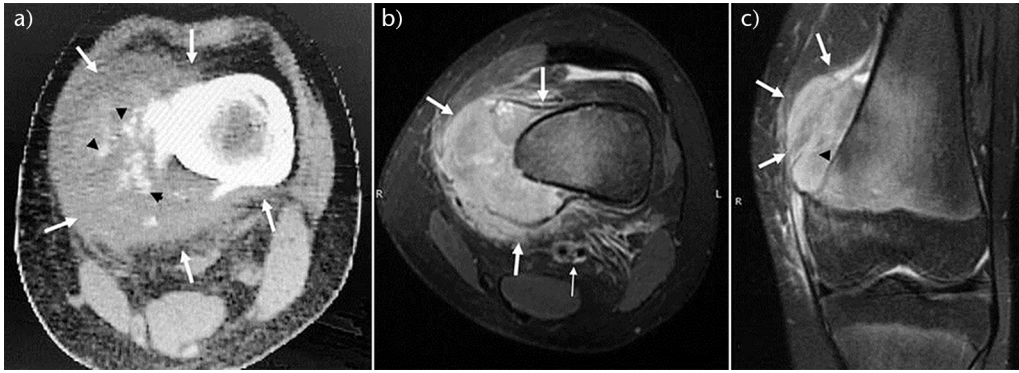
(A) A computerized tomography (CT) scan shows a cortical broad-based soft tissue mass (arrows) at the distal metaphysis of the left femur which surrounds about 50% of bone circumference. The tumour contains amorphous calcifications, and the adjacent cortex is thickened on this slice. (B, C) An axial (B) and a coronal (C) fat-suppressed T2w magnetic resonance (MR) image demonstrate the bulky tumour (arrows) originating at the medial site of the left femur. The tumour is moderately hyperintense and presents significant intramedullary extension (arrows). At the distal margin of the tumour on the coronal image the bone cortex looks thinned (C). The neurovascular bundle remains intact in B (thin arrow). Note that the calcifications are not apparent on MR images.
